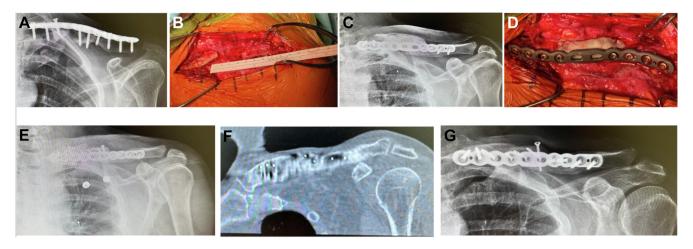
(A) 50-year-old woman with failed clavicle fixation (hardware failure and *C. acnes* sepsis), (B) associated with a 3.7 cm bone defect. (C, D) Hardware removed, cement, and anterior plate placed. (E) After seven weeks, second stage for placement of a tricortical bone graft fixed additional screw within the induced membrane cavity. (F) CT scan and (G) radiograph at four months after the operation show bone healing.
